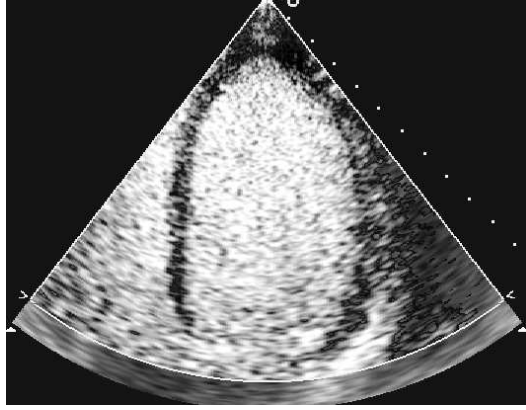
Frame of contrast Echocardiography. The inverted U-shape is the structure to be segmented, the myocardium seen in the long axis view.
